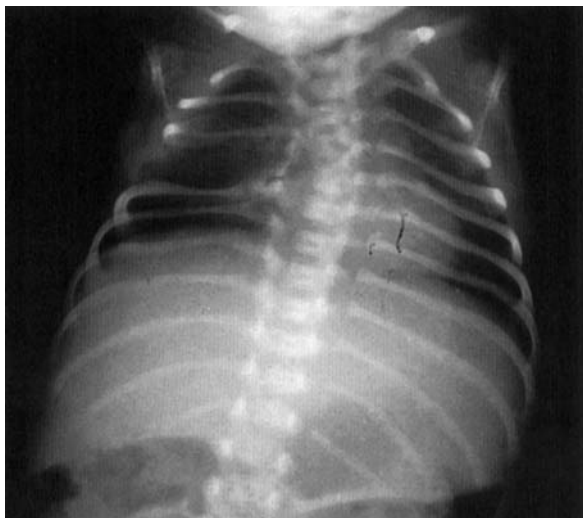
Anteroposterior radiographic film of the thorax of patient 7, showing only two missing ribs on the right side.
